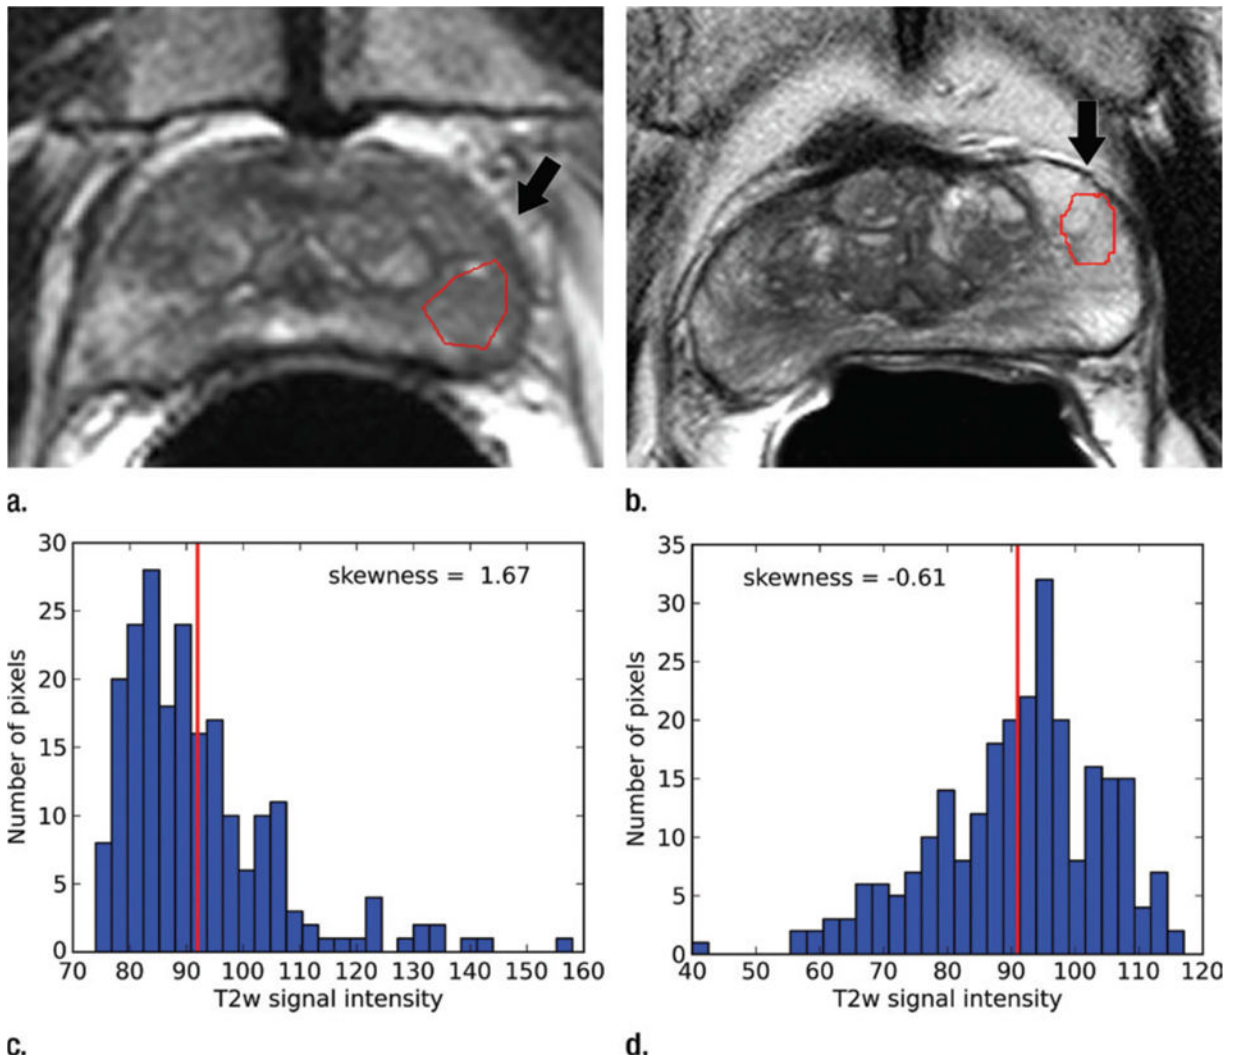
T2-weighted MR images show (a) a tumor (arrow) in a 66-year-old man with a GS of 7 (4+3) and a prostate-specific antigen level of 13.02 ng/mL and (b) an area of PZ normal tissue (arrow) in a 64-year-old man with prostate cancer elsewhere. Red outlines indicate ROIs. (c, d) Corresponding histograms show T2-weighted signal intensities within the ROIs and the corresponding skewness image feature values. The tumor ROI has more dark pixels than bright pixels, whereas the normal tissue ROI has more bright pixels than dark pixels. Red lines in c and d identify the average, T2-weighted signal intensity within each ROI.
